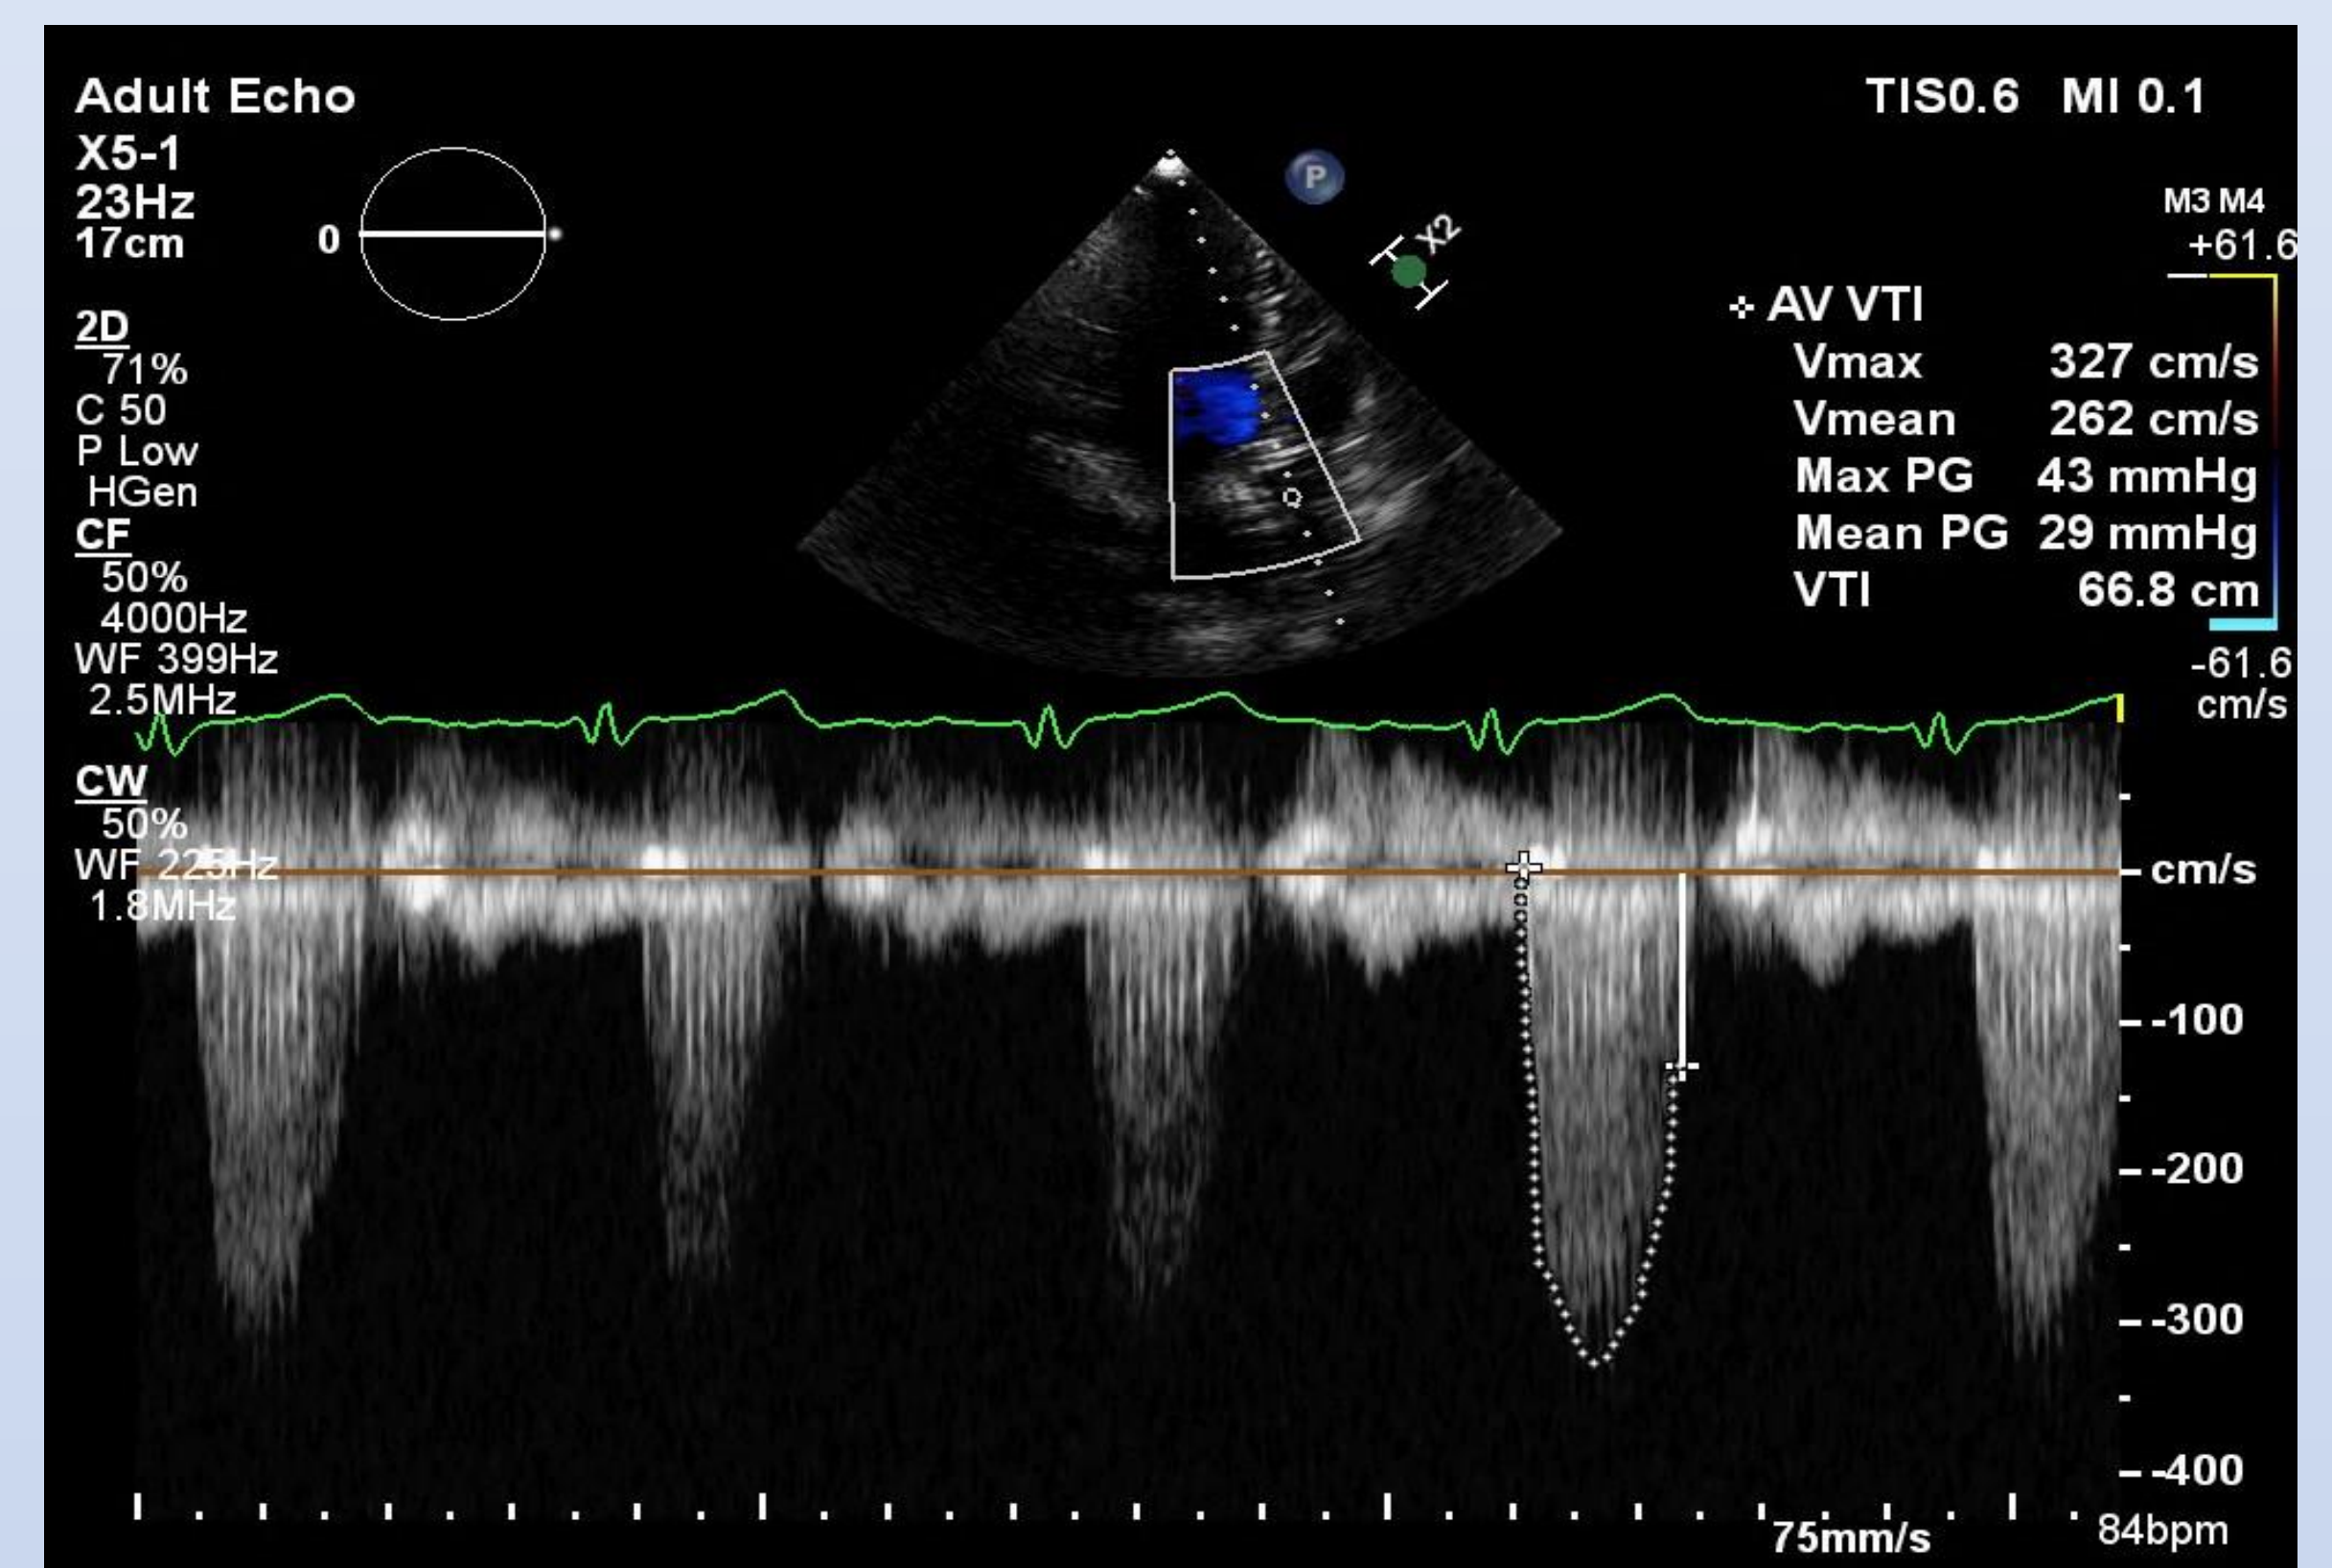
The 12 months post TAVI echocardiography of the patient
